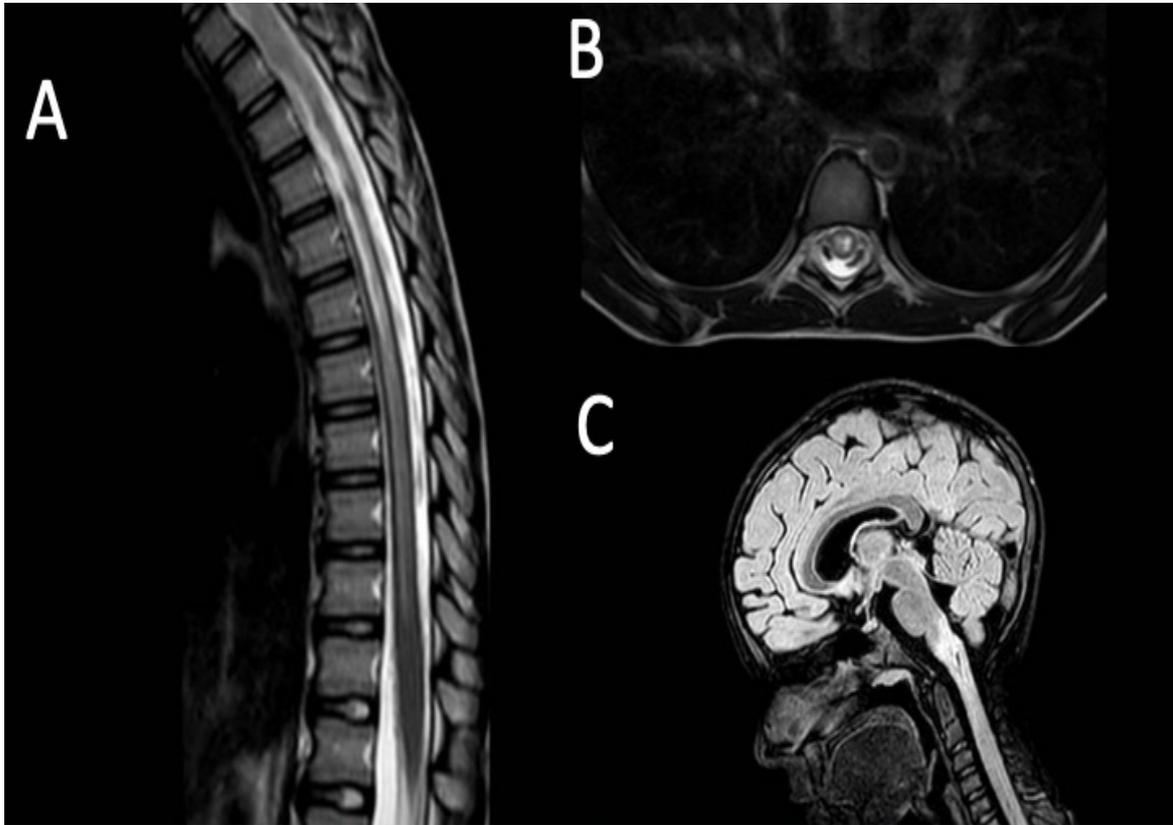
A- Imagem de RM em sequência T2 com cortes sagitais demonstrando mielite longitudinal extensa em região dorsal; B – Imagem de RM de coluna dorsal sequencia T2 em cortes axiais demonstrando mielite central com “Bright Spot Lesions” ; C – RM Imagem de RM encéfalo em sequência FLAIR axial demonstrando alteração de sinal em bulbo e transição bulbomedular. Paciente 18 anos DENMO anti-AQP4+.
